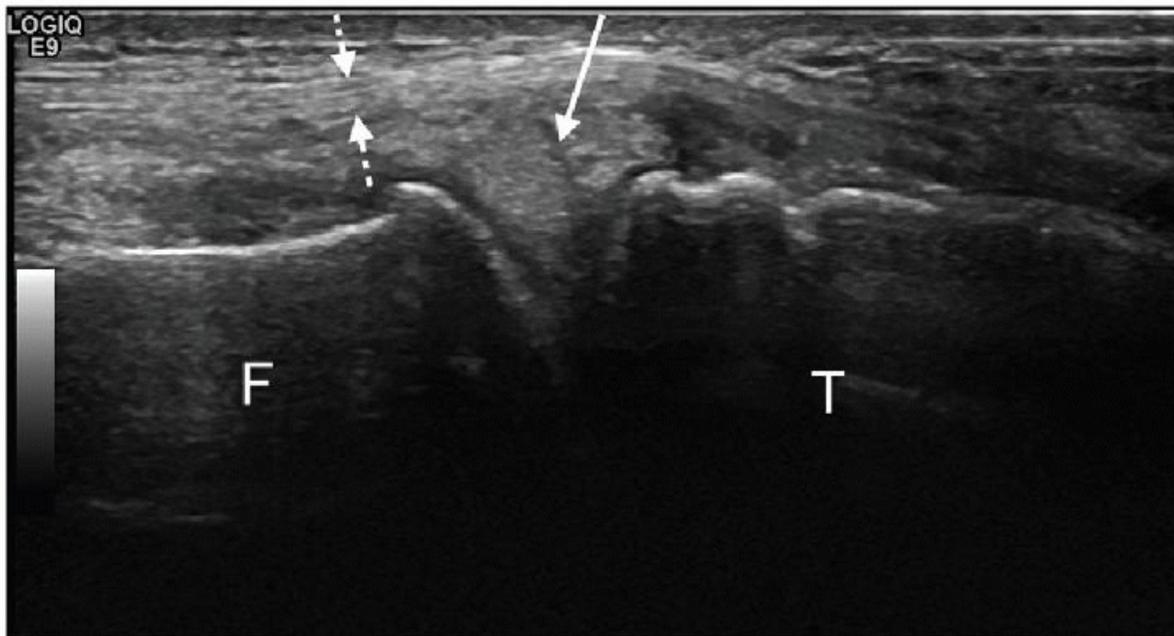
Longitudinal ultrasound image of the medial meniscus demonstrating an axial split tear (solid arrow). Dashed arrow = MCL. Iliotibial Band Tendinopathy
